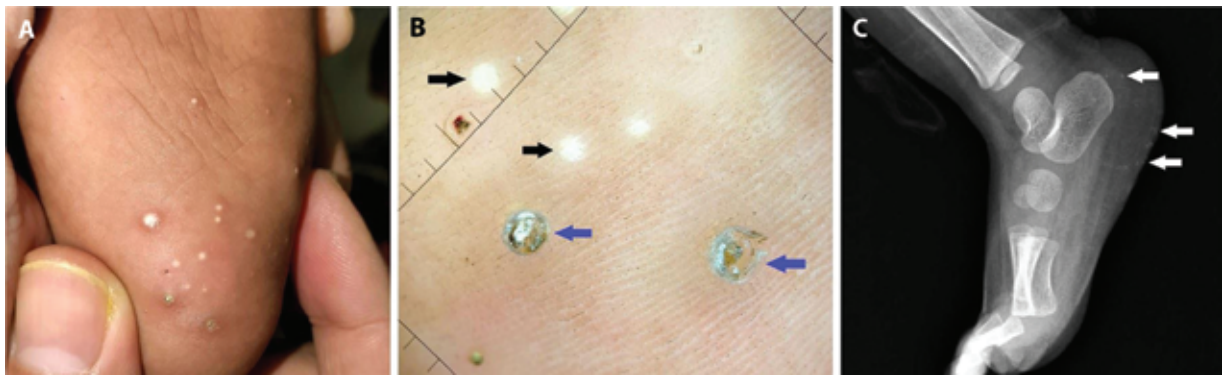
Dermoscopy: polarized, x20. (A) Multiple discrete white and keratotic papules on the heels. (B) Dermoscopy shows well-defined homogenous white dots (black arrows) and keratotic lesions with central yellow and white amorphous clods surrounded by concentric thick scales (blue arrows). (C) Plain X-ray shows circumscribed opaque densities along the margins of the heel
